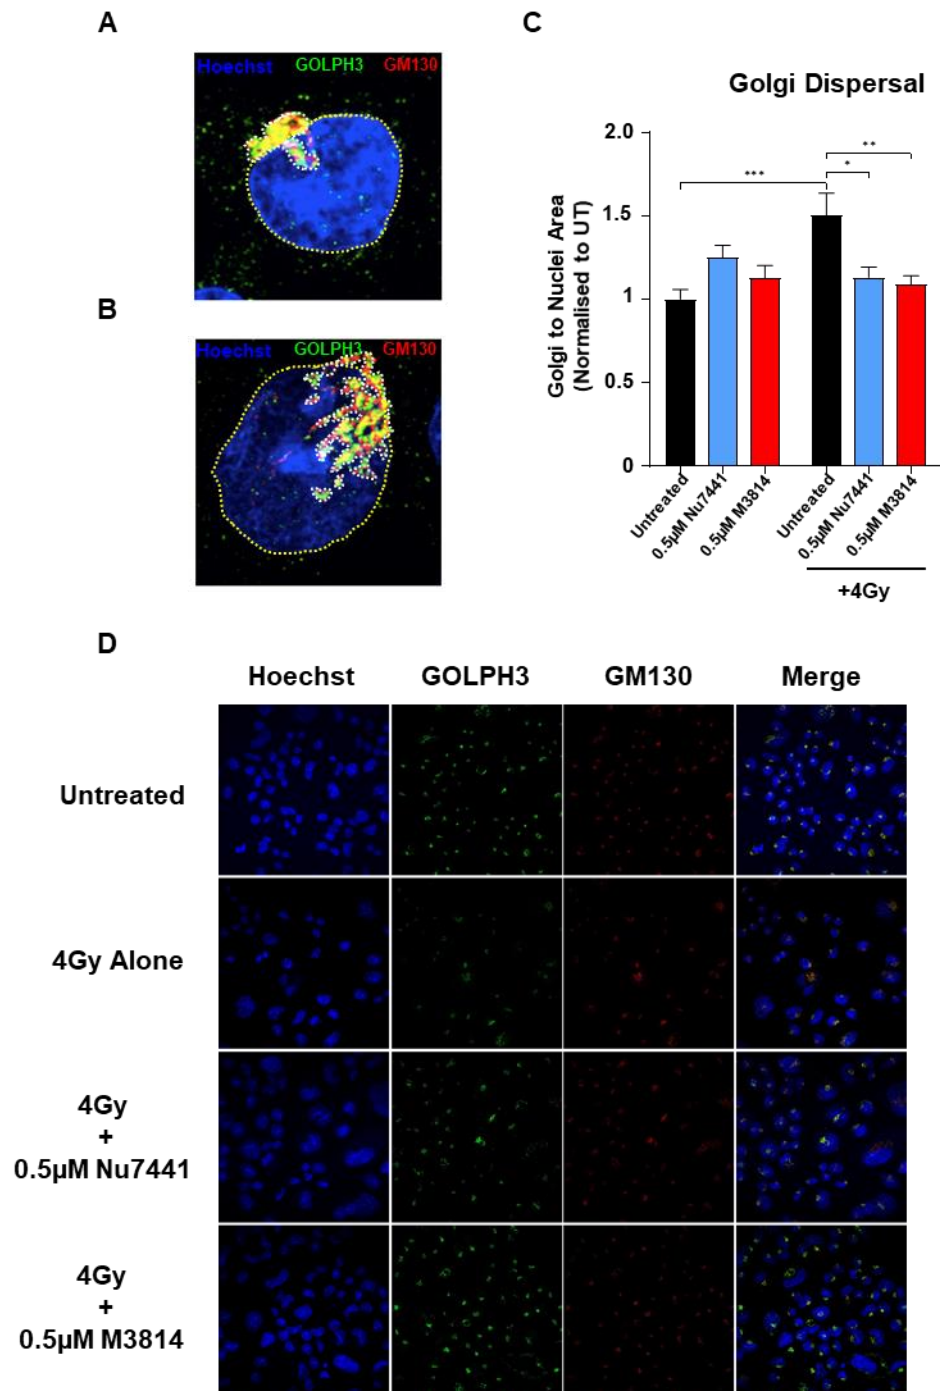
7. DNA-PKi abrogates X-ray induced Golgi fragmentation.
